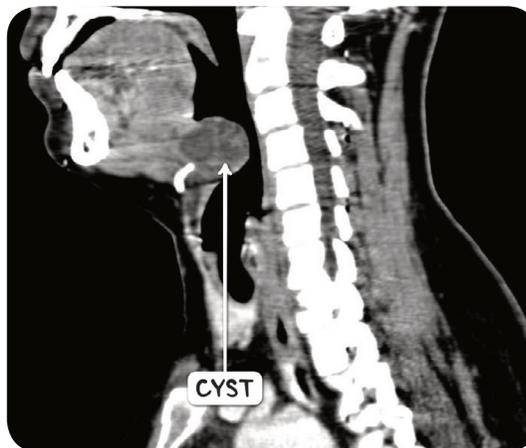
A CT scan of the head and neck in the sagittal plane demonstrating a thyroglossal duct cyst adjacent to the hyoid bone.
